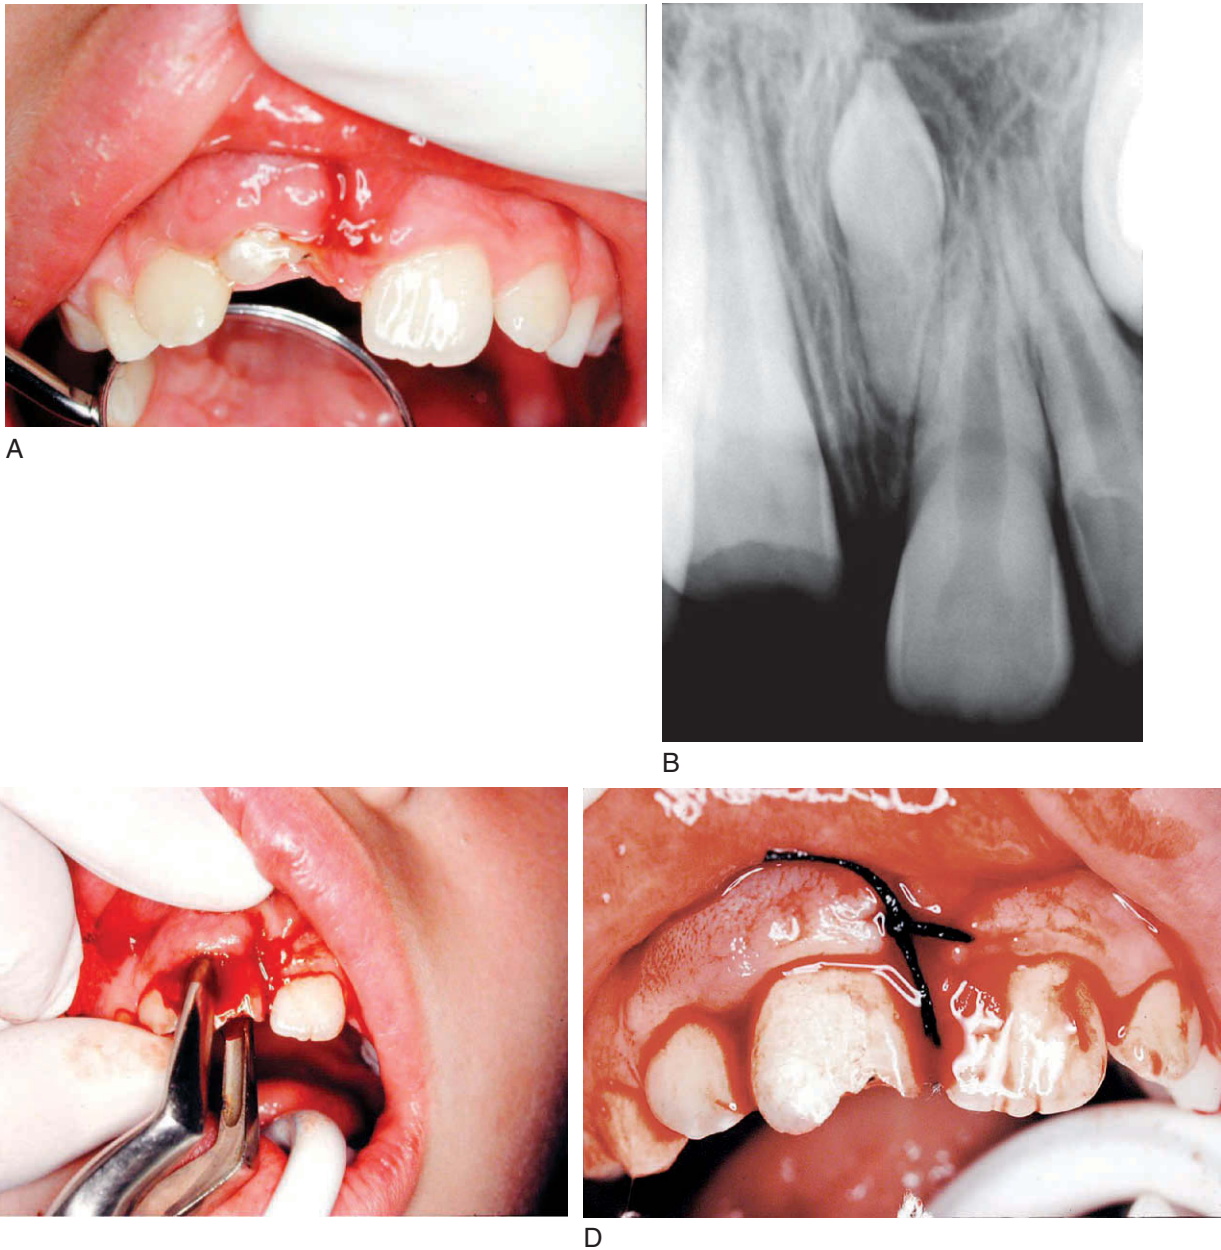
Maxillary right central incisor with intrusive luxation and surgical extrusion of tooth. A, Clinical appearance of intrusive luxation and uncomplicated crown fracture and gingival laceration. B, Radiograph showing intrusion, compressed PDL, and mesiodens. C, Repositioning of tooth with extraction forceps. D, Tooth in position with sutured gingival laceration. Today nylon sutures are recommended, not silk as shown here. *Continued*
